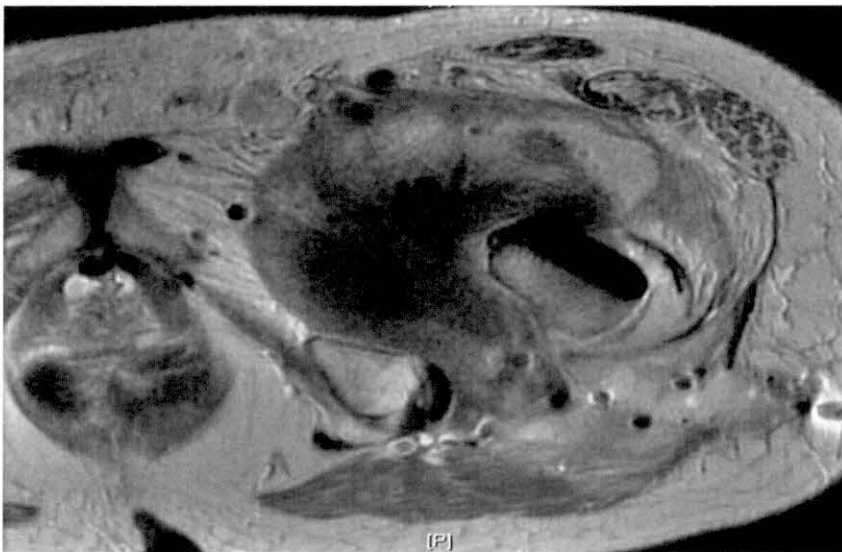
MRI image showing a larger pseudotumor resulting from metal sensitivity [84]
